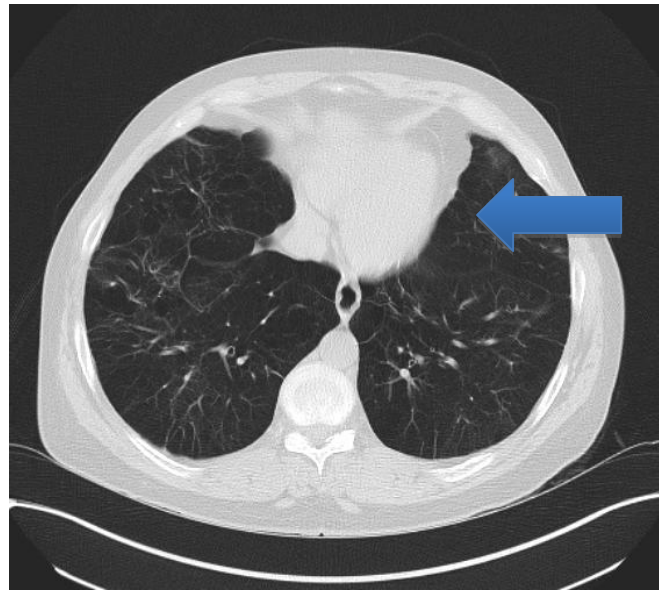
Appearances of emphysema on CT. This is a scan of the thorax at the level of the heart. It represents a cross-sectional slice of tissue viewed as if you are looking towards the patient's head. There is enlargement of airspaces and tissue destruction throughout both lungs (highlighted).
